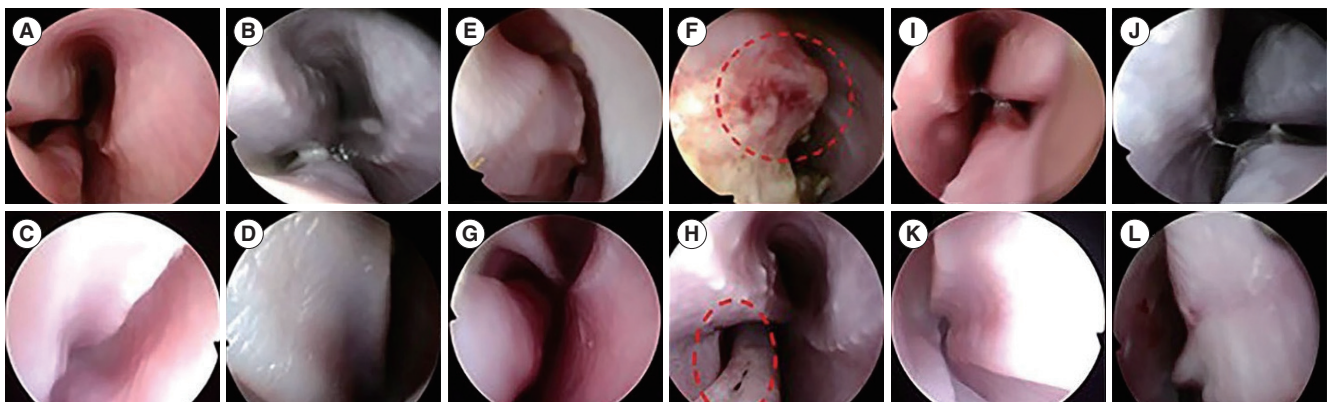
Nasal endoscopic findings in the control, radiofrequency, and high-intensity focused ultrasound (HIFU) groups. (A, B) Preoperative and postoperative findings in the control group (week 1). (C, D) Preoperative and postoperative findings in the control group (week 4). (E, F) Preoperative and postoperative findings in the radiofrequency group (week 1). (G, H) Preoperative and postoperative findings in the radiofrequency group (week 4). The red circle in (F) indicates eschar formation, bleeding, and crust formation, while the red circle in (H) indicates scar formation. (I, J) Preoperative and postoperative findings in the HIFU group (week 1). (K, L) Preoperative and postoperative findings in the HIFU group (week 4).
